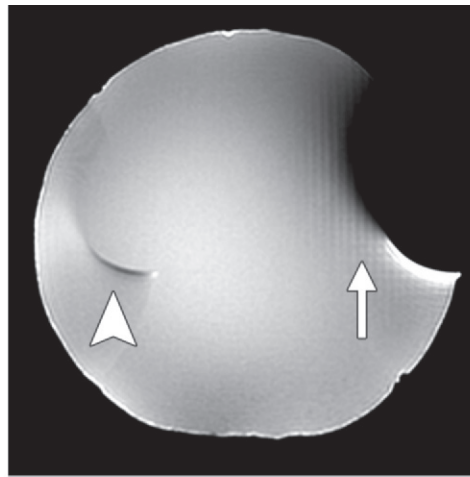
Motion artifact. Axial T2-weighted 2D parallel MR image shows a motion artifact.
